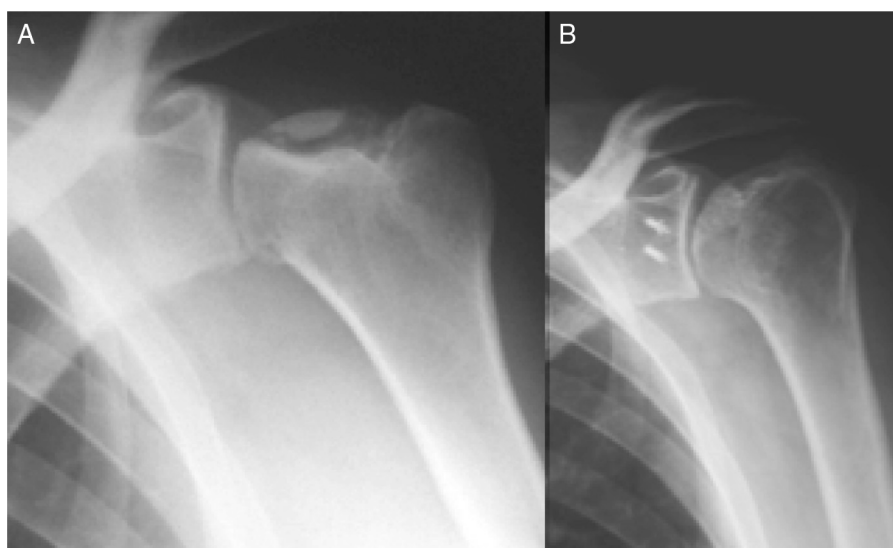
(A) Preoperative radiographic image of the left shoulder in anteroposterior view, showing segmental necrosis of the humeral head; (B) radiographic image of the same patient 14 years after surgery, showing the integrated graft.
